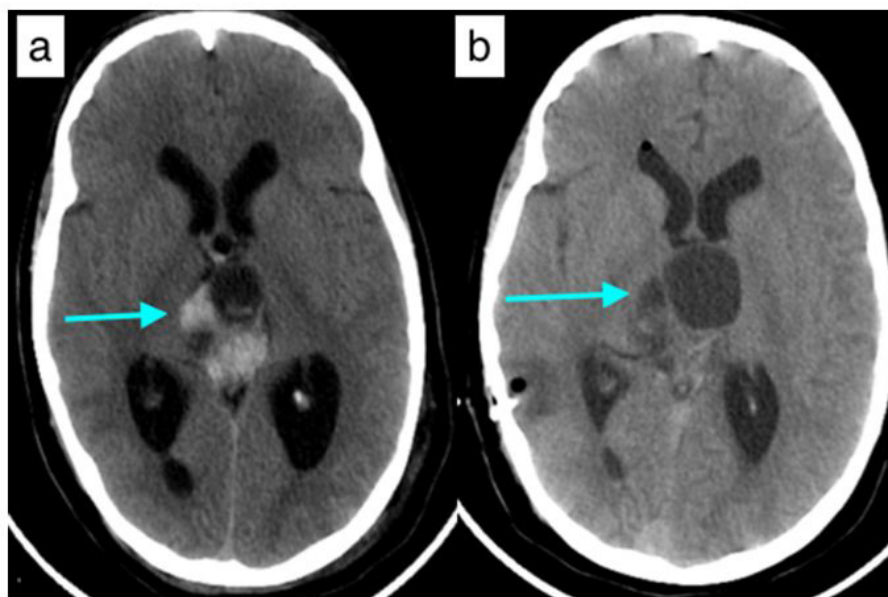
Axial CT scan slide showing the tumor with hydrocephaly (a) Post-derivation aspect without hydrocephaly (b)
